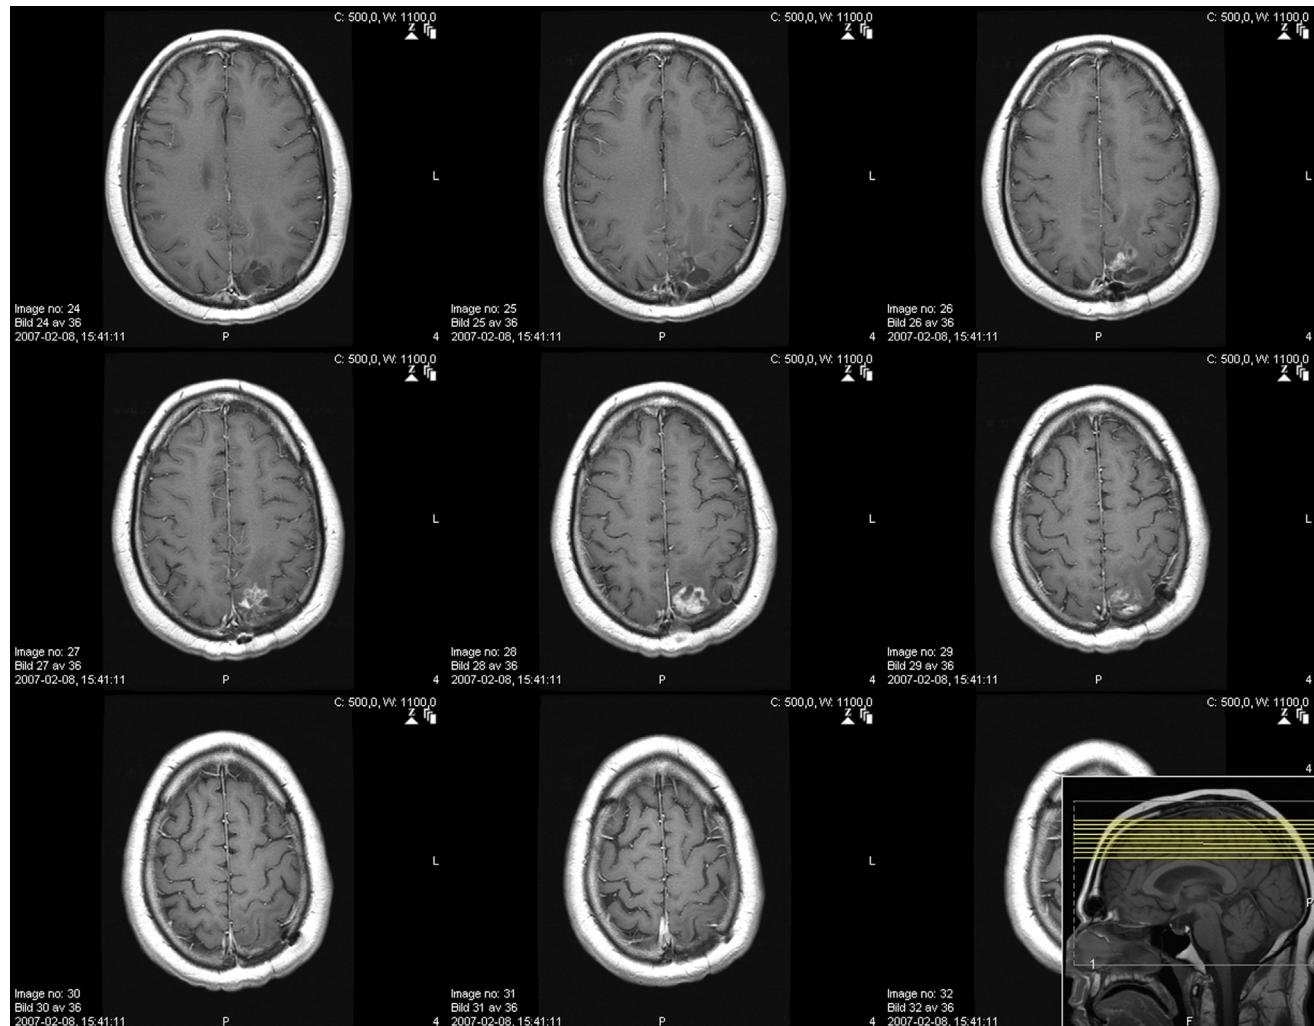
Follow-up magnetic resonance imaging; February 2007.
